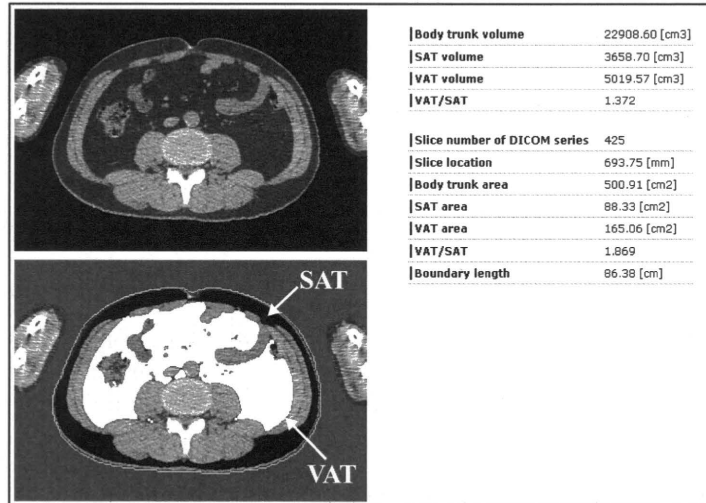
Result of volumetry of VAT and SAT in whole-body CT images. The upper image shows a CT image in an umbilical slice, and the lower image shows extracted fat regions. The black area represents SAT, and the white area represents VAT. The right table shows measurement results.
